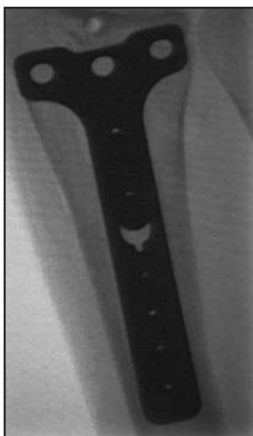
Fluoroscope x-ray for proper position
